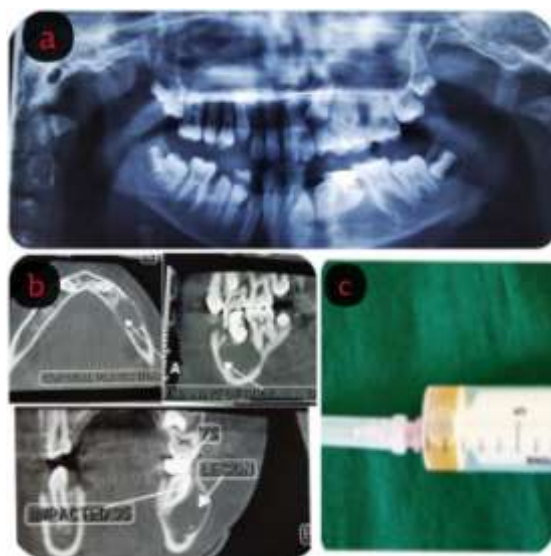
(a): Panoramic radiograph, (b): CT Images showing the presence of a well-defined unilocular hypodense lesion on the left side of the mandible, involving the periapical region of 75 and horizontally impacted 35, (c): Straw-colored aspirated fluid.
